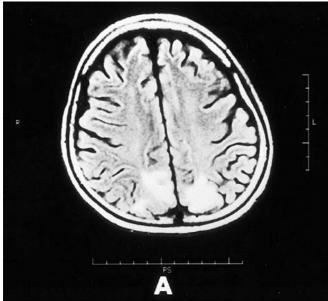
T2-weighted MRI scans. A Areas of hyper-intense signals on T2-weighted fluid-attenuated inversion-recovery images involving parieto-occipital lobes bilaterally. The follow-up MRI (B) reveals the complete resolution of abnormal signals
